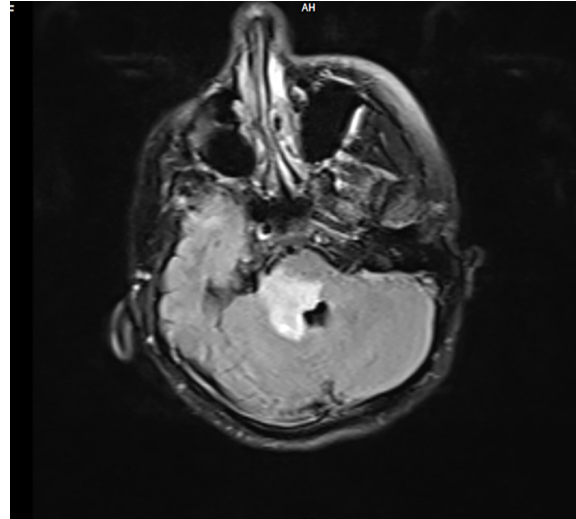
The figure shows a brainstem tumor MRI in a pregnant patient with contrast enhancement. The soft tissue involvement is prominent in the image.
